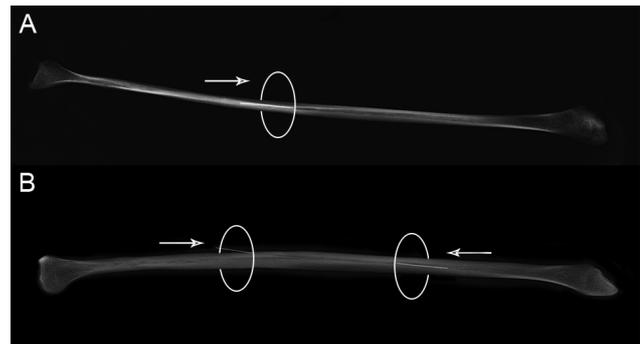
Radiographic images of the fibula with a hypodermic needle inserted into the nutrient foramen. (A) Fibula with single nutrient foramina directed distally. (B) Fibula with double nutrient foramina directed both distally and proximally.
